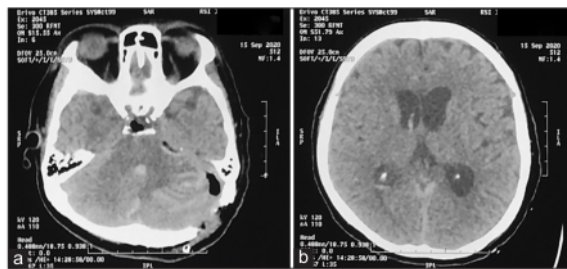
CT imaging early postoperative shows cerebellar edema and hemorrhagic on cerebellum (a) and hydrocephalus (b).
